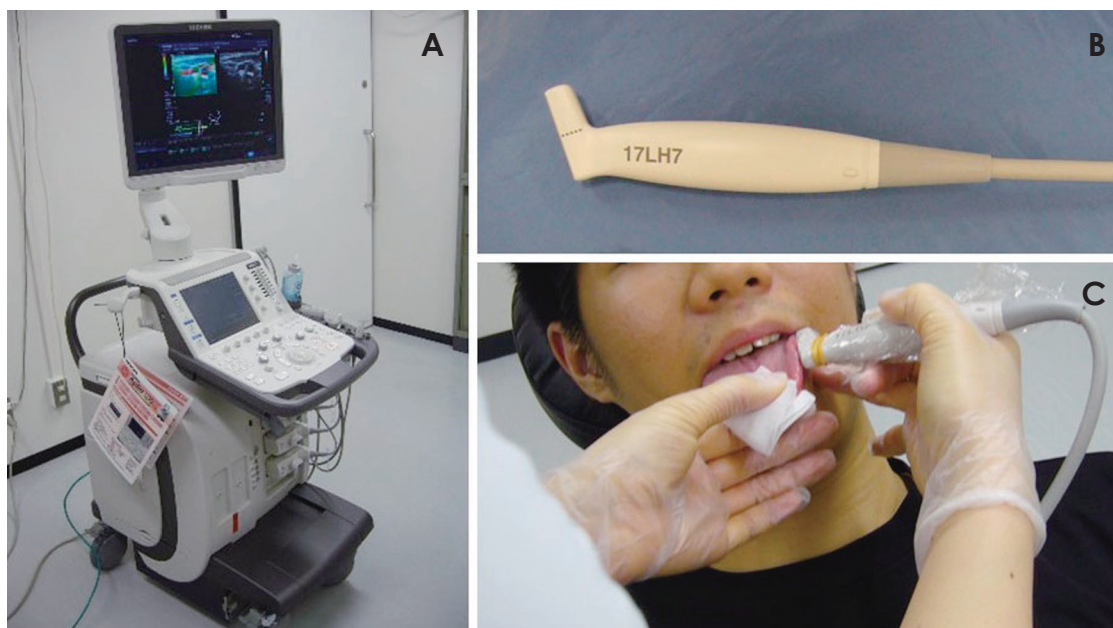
A. Ultrasonography unit with a linear 14 MHz transducer. B. Ultrasonography probe for an intraoral ultrasonographic examination. C. Ultrasonographic examination of the tongue.
